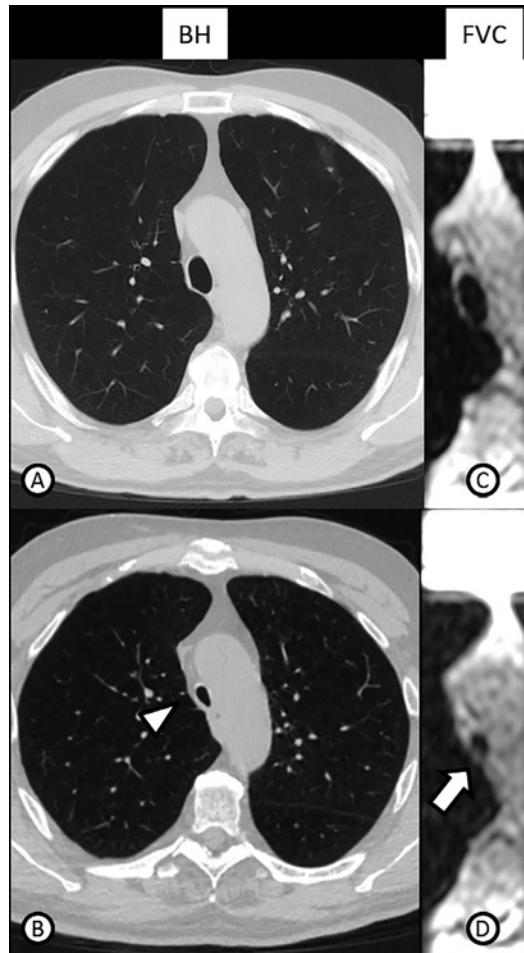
Static and dynamic MRI and CT scans in a patient with saber-sheath tracheobronchomalacia (TBM). Breath-hold end-inspiratory (A) and dynamic-expiratory (B) axial CT reformats. Forced vital capacity (FVC) inspiratory (C) and maximum dynamic expiratory (D) axial MRI reformats. Note severe lateral tracheal collapse during FVC maneuver both with CT (arrowhead) and with cine-MRI (arrow).
